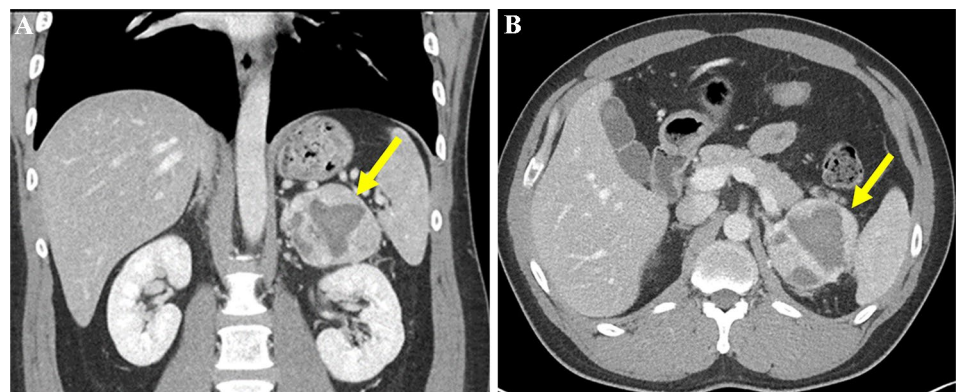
A 7 cm left adrenal cystic pheochromocytoma (arrow) detected incidentally on CT done for RLQ pain. Arterial phase coronal (A) and venous phase axial (B) CT images performed prior to surgery show peripheral hyperenhancement with arterial phase attenuation of 157 HU (A), venous phase attenuation 105 HU (B), and central low attenuation of 50 HU representing necrosis and cystic changes
